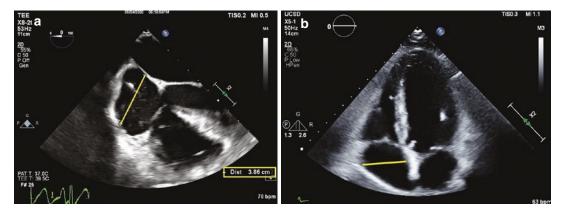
(a) Midesophageal four-chamber view demonstrating linear size measurement of the right atrium (*yellow line*). (b) Apical four-chamber view demonstrating linear size measurement of the right atrium (*yellow line*)
